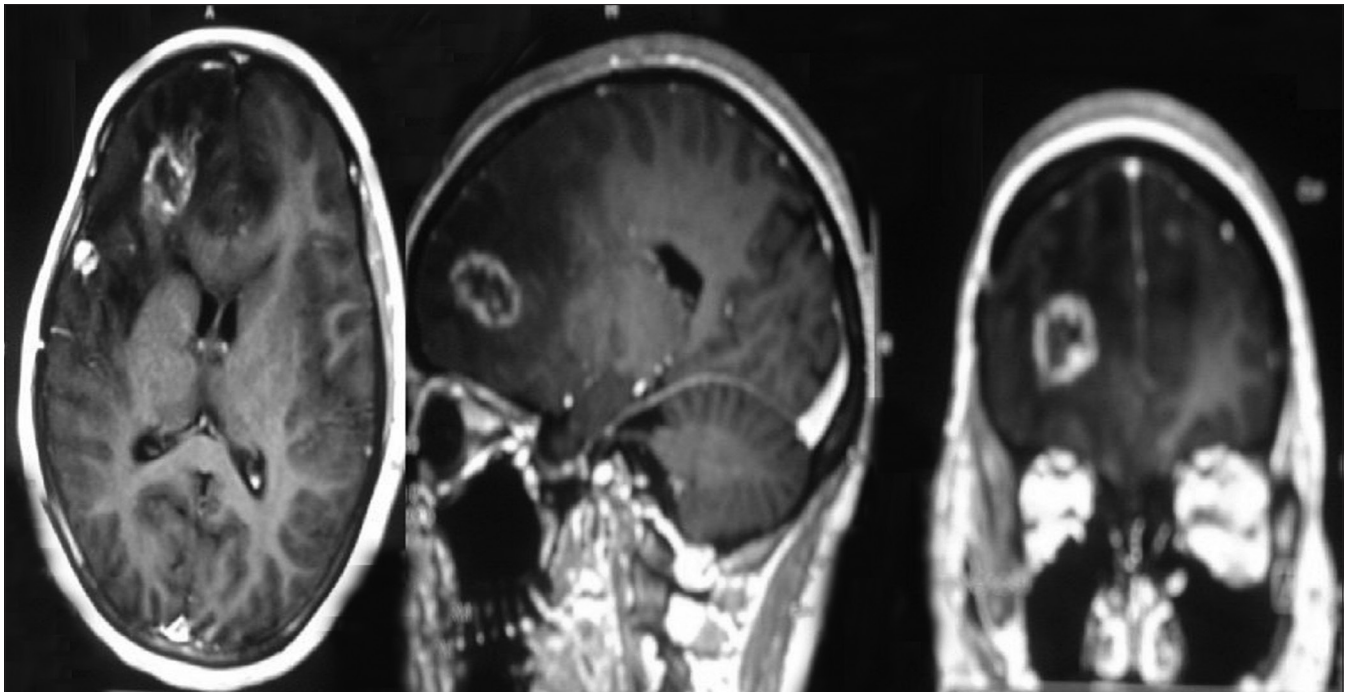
Positron emission tomography-magnetic resonance images
